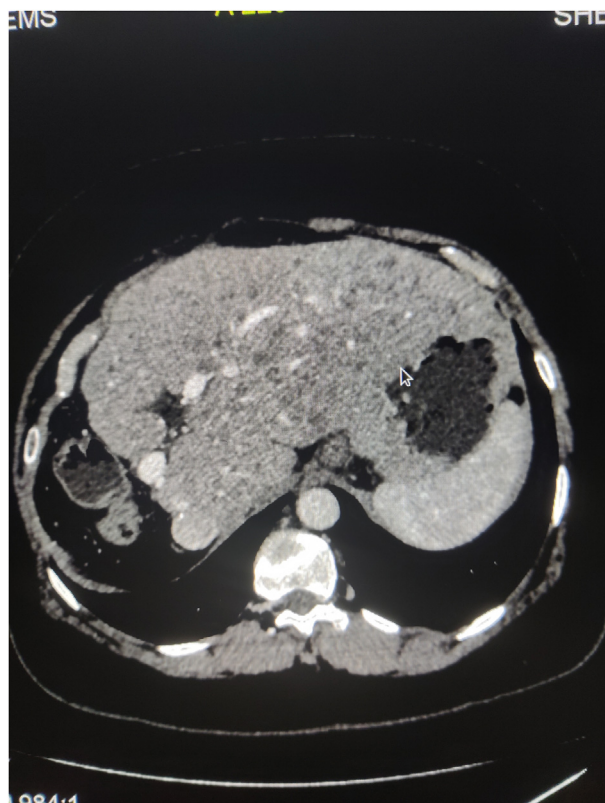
Axial computed tomography section of upper abdomen in venous phase. Arrow – the liver shows altered attenuation with hypertrophy of caudate and rest of remnant liver. Surface appears irregular with multiple regenerative nodules.
